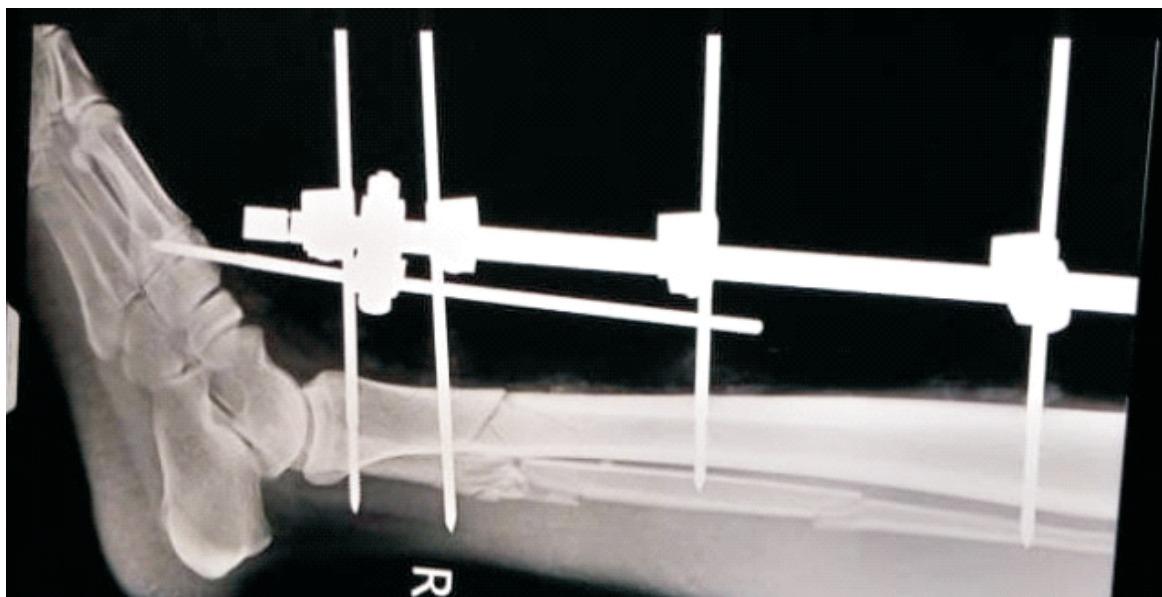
Post-operation Xray (lateral view) of the limb of the Patient in 2A & B.
